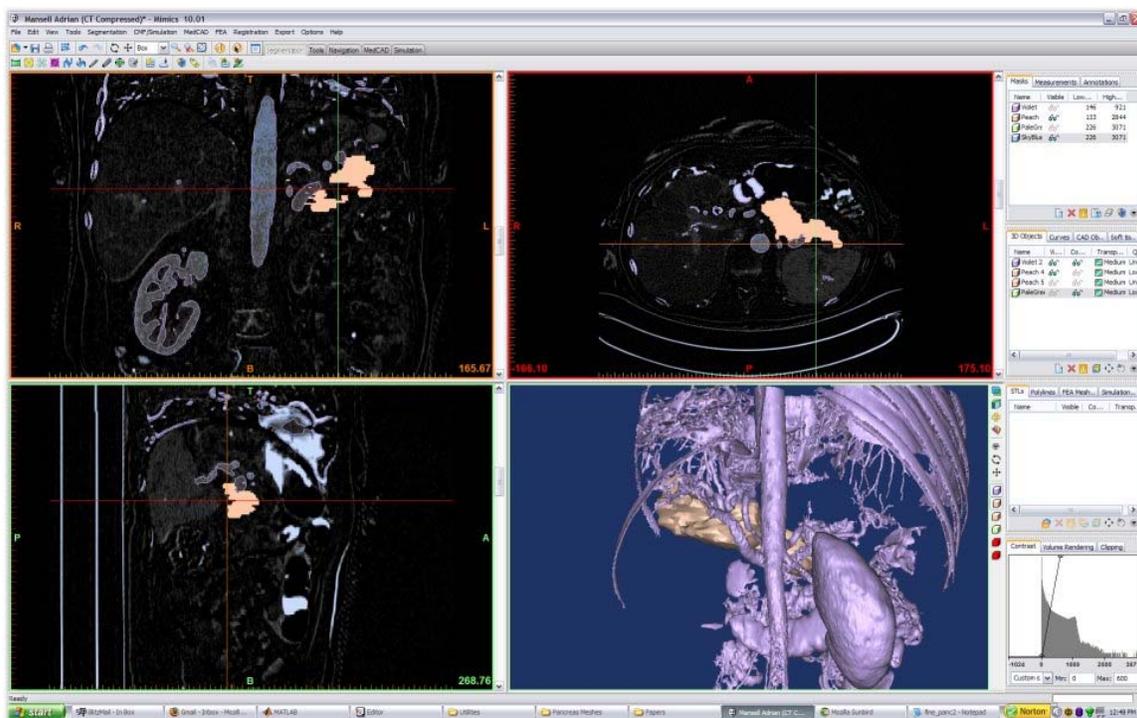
Screenshot of the difference between pre and post contrast CT scans. The pancreas has been segmented in this image, and can be seen as the tan sections, and as the tan object in the 3D rendering of areas with high perfusion. The patient moved between the pre and post contrast scans due to breathing, and as a result the ribs show up as having large amounts of blood flow. The difference image was used to estimate blood flow, which was then used to estimate the heterogeneities in the optical properties of the tissue.
